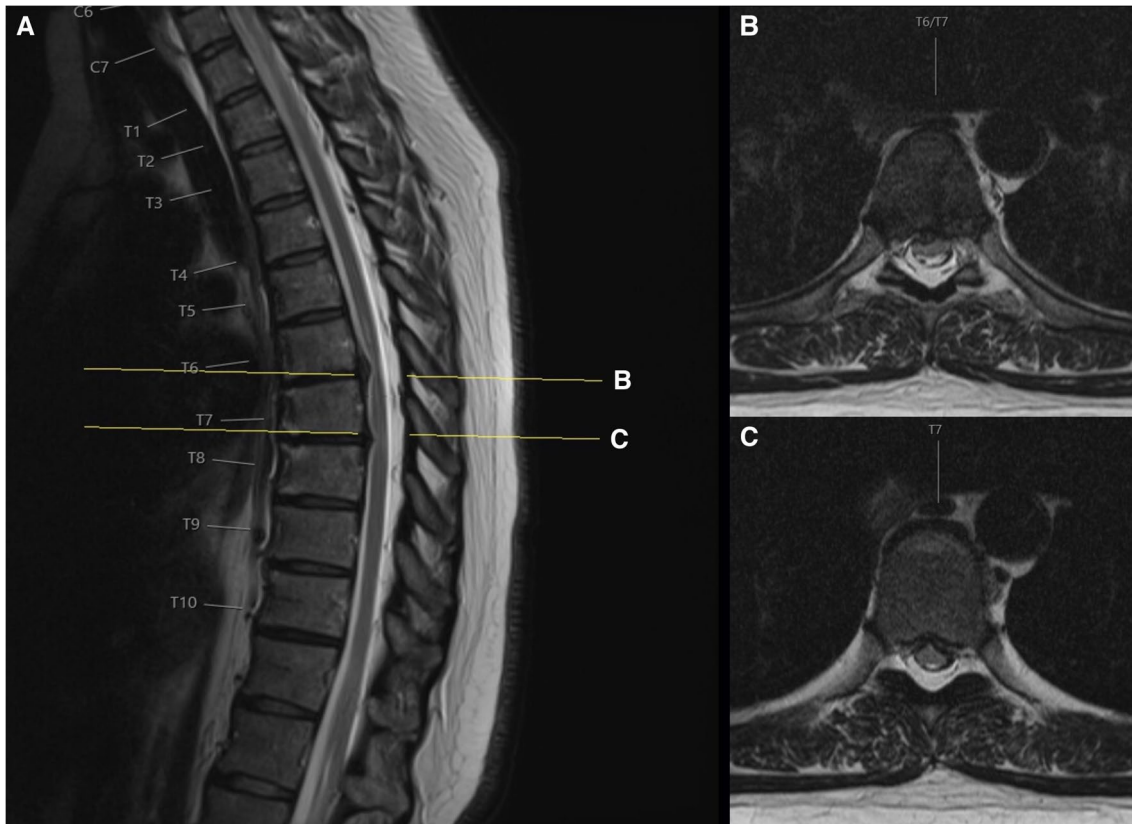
Sections of the pre-operative T2 magnetic resonance image (MRI). A. Midsagittal view with yellow lines indicating the level of the transverse sections displayed in B and C. Images show a clear
